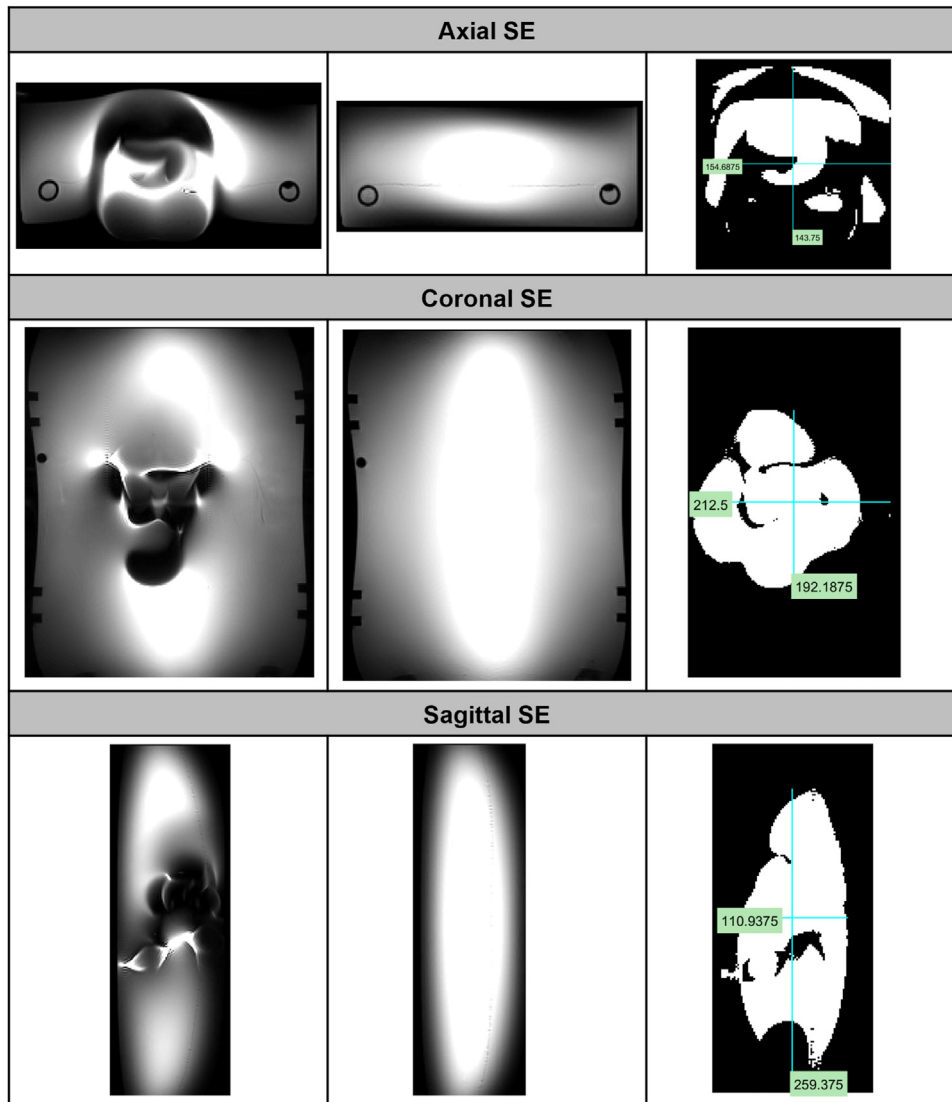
CoCr knee with a spin echo pulse sequence in a 3T MRI system. Worst-case image (left), background image (middle), resulting image artifact (right). Measurements are in millimeters.
